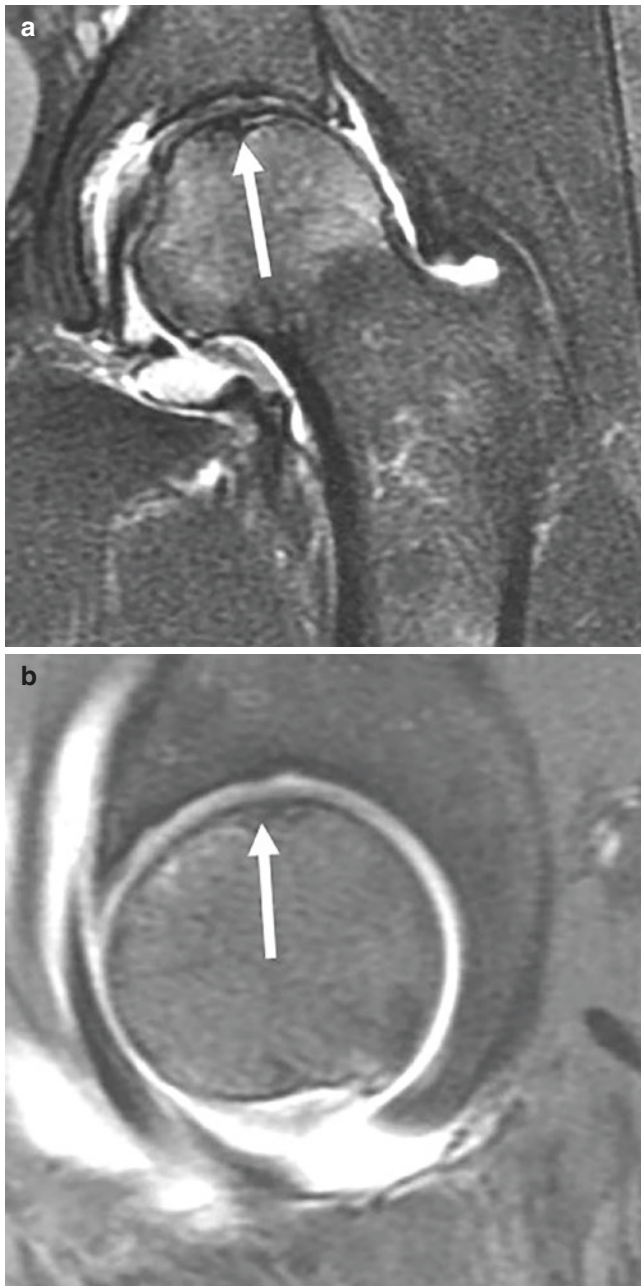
Coronal T2 fat-suppressed (a) and sagittal PD fat-suppressed (b) MR images in a 51-year-old woman demonstrates subchondral insufficiency fracture (arrows). A subchondral linear band of low signal is present beneath the femoral head with surrounding bone marrow edema
